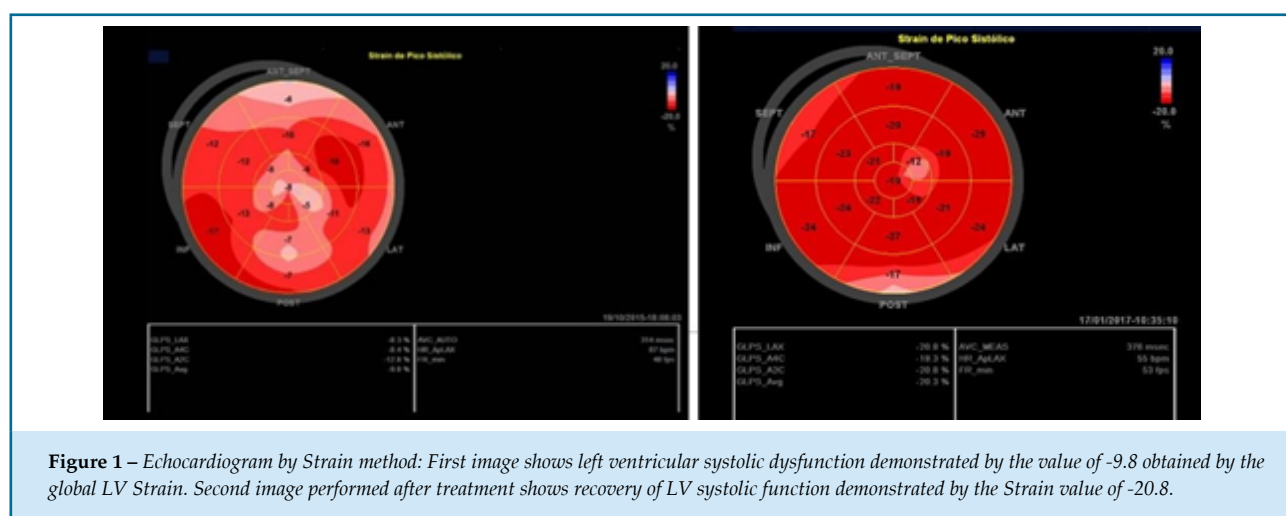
Echocardiogram by Strain method: First image shows left ventricular systolic dysfunction demonstrated by the value of -9.8 obtained by the global LV Strain. Second image performed after treatment shows recovery of LV systolic function demonstrated by the Strain value of -20.8.
